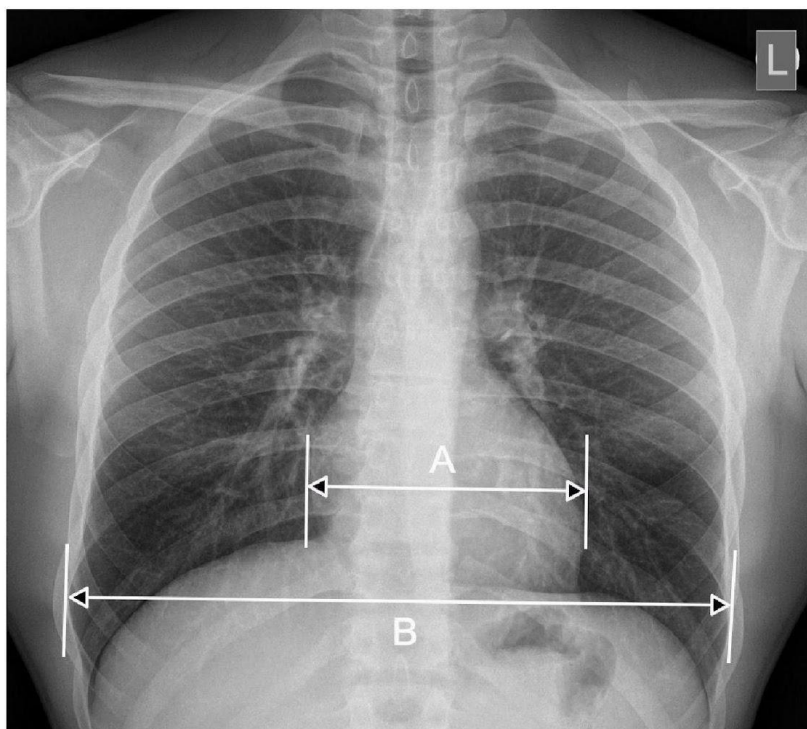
The method of determining the CTR. The CTR is determined on the basis of the ratio of the transverse heart dimension [A] to the transverse dimension of the chest (internal ribs) [B] measured on the radiograph in the chest PA projection: $CTR = A/B$.
